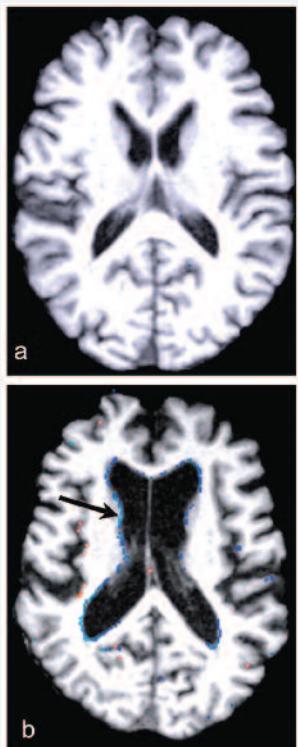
MRI subtraction scans at 5 y intervals of two normal elderly subjects. a) Subject (aged 79 y): plasma vitamin B12 553 pmol/L at base-line; whole brain atrophy rate 0.28% per y. b) Subject (aged 76 y): plasma vitamin B12 at base-line 192 pmol/L; whole brain atrophy rate 1.7% per y. The blue pixels (arrow), mainly around the ventricles, show where the tissue has shrunk (atrophy) more than 1 mm between scans. See Vogiatzoglou et al., *Neurology* 2008; 71:826–832.
